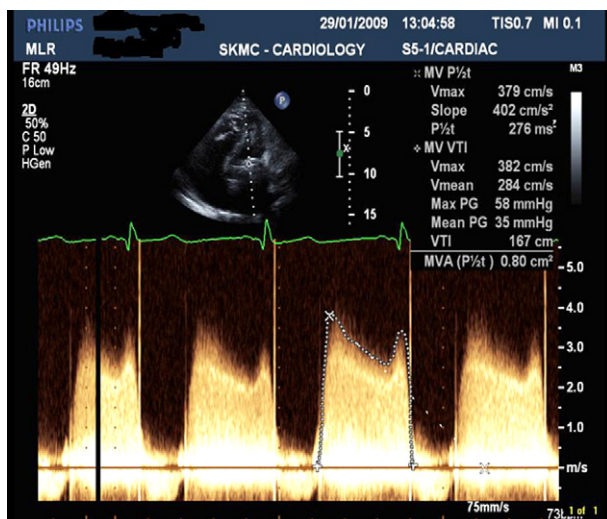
Continuous wave Doppler study showing a markedly elevated gradient across the prosthetic mitral valve before tenecteplase.
